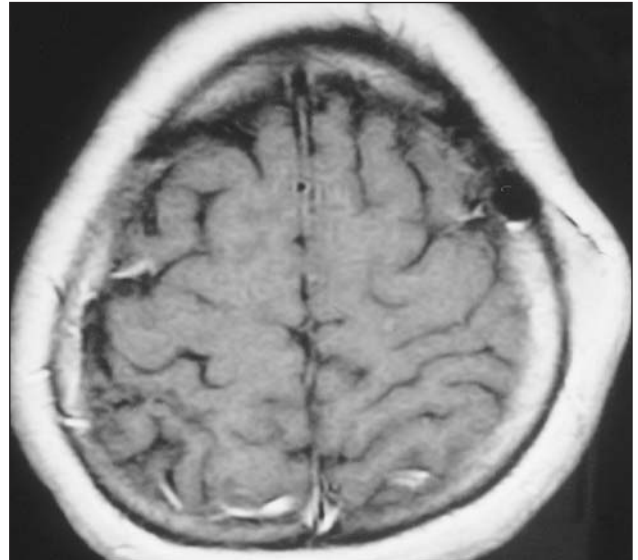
Axial T2-weighted magnetic resonance imaging revealed isointense mass in the subcutaneous tissue.
